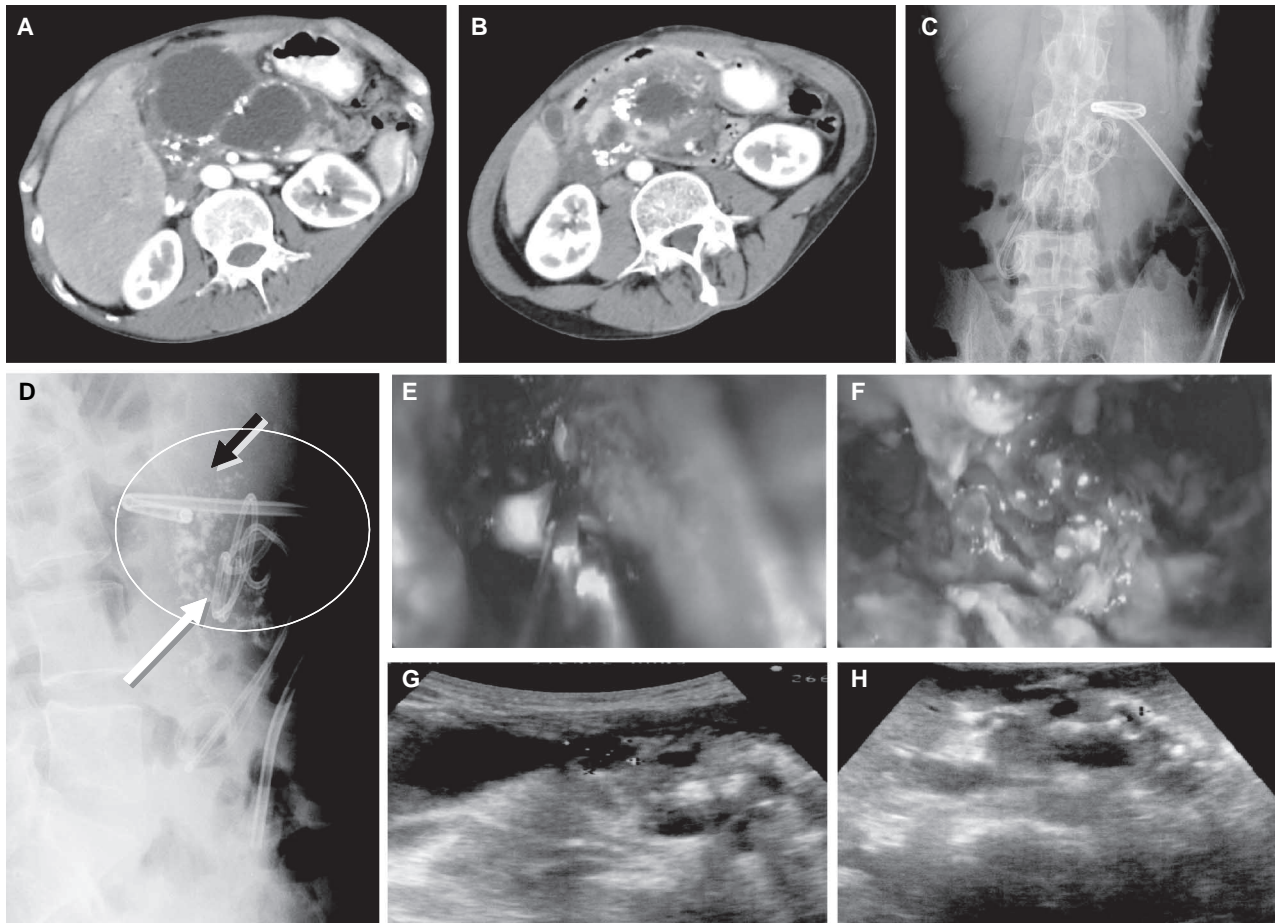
A 42-year-old man presented with an acute episode of alcoholic chronic pancreatitis. During the course of the disease he developed an infected pancreatic pseudocyst as shown on the CT scan (A and B). To achieve rapid drainage a percutaneous CT-guided catheter was inserted (C, plain radiograph), but this did not lead to resolution of the cyst. In a second step a pigtail catheter was inserted via puncture of the duodenal wall (D, plain radiograph). The pigtail catheter spontaneously dislocated into the cyst. By needle knife incision from the duodenum into the cyst we recovered the dislocated stent and endoscopically cleared and rinsed the cystic cavity every other day (E and F). The patient was discharged without any further complications 8 days after the salvage of the pigtail catheter. Three months later transabdominal ultrasound examination revealed a small residual cyst (G), as well as a dilated pancreatic duct (H) but no further complication.
